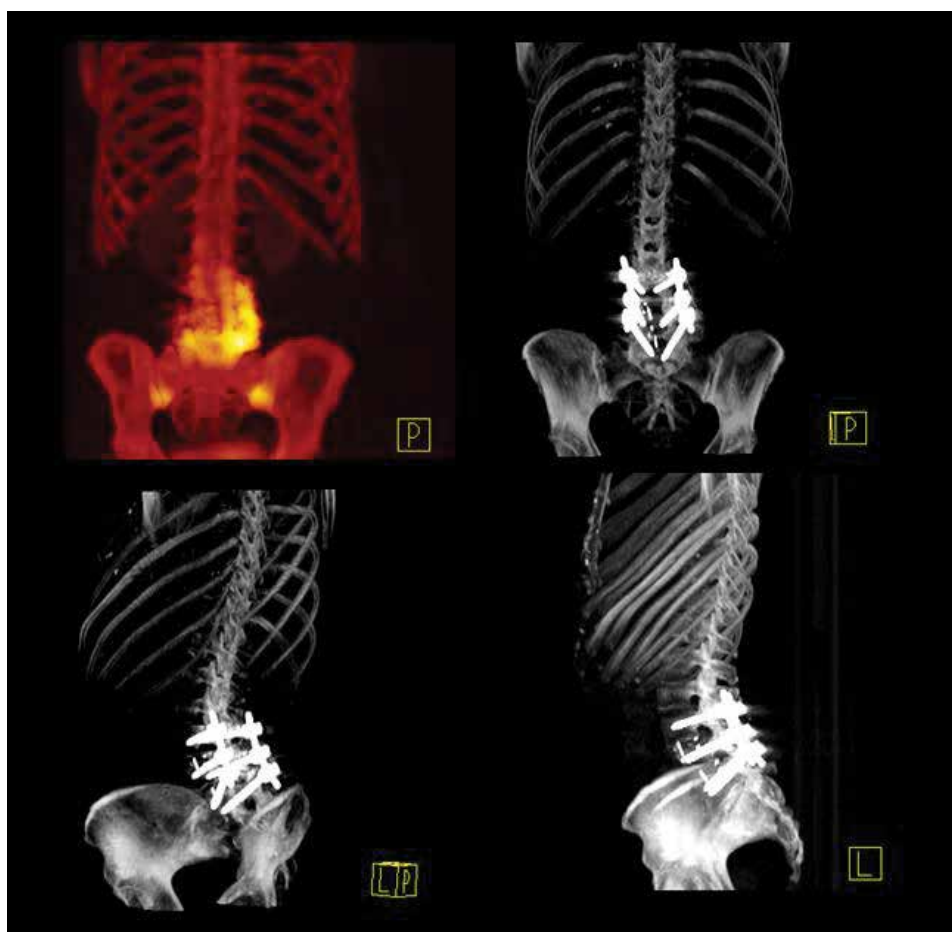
Posterior, oblique and lateral views of the MIP of xSPECT Bone and CT show the increased hypermetabolism and the corresponding right lower lumbar screw.
